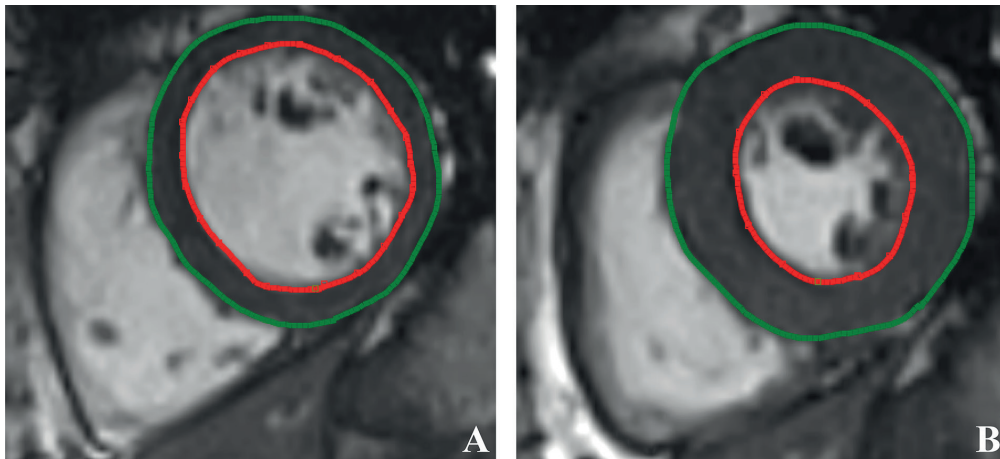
Cardiac magnetic resonance images of a 42-year-old female with systemic sclerosis. Short-axis b-SSFP images determining end-diastolic (green) (A) and end-systolic (red) (B) for measuring LVEF. LVEF was decreased to 62%. Abbreviations: b-SSFP, balanced steady-state free precision; LVEF, left ventricular ejection fraction.
